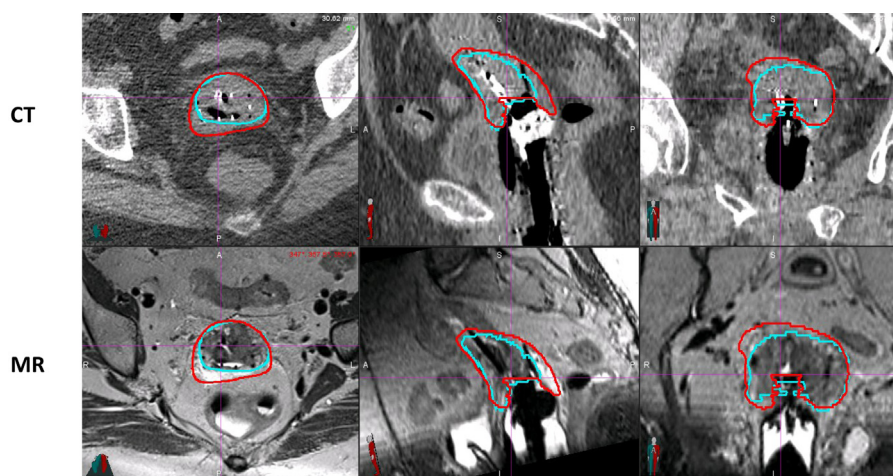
Axial, sagittal, and coronal computed tomographic (CT) and magnetic resonance (MR) images for case 1 showing a tandem and ovoid applicator with consensus contours for MR (light blue) and for CT (red).
